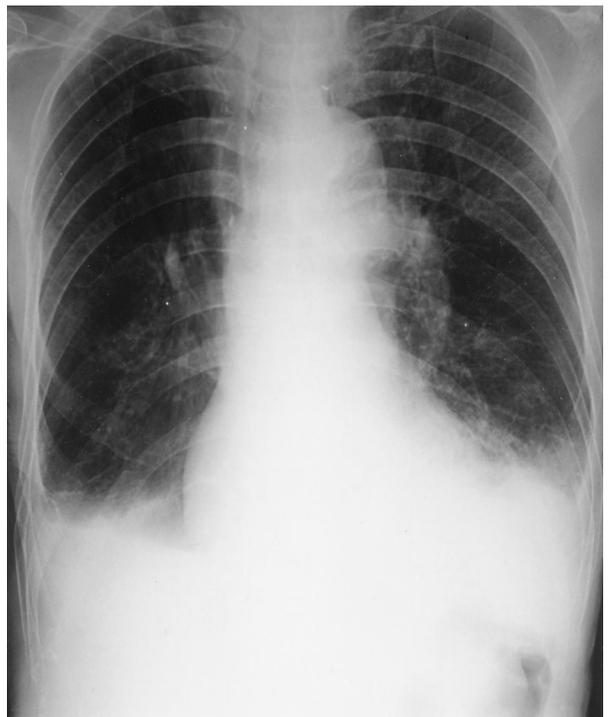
Chest radiograph showing hyperlucent lungs, a left pleural effusion, and signs of a previous right upper lobectomy.
